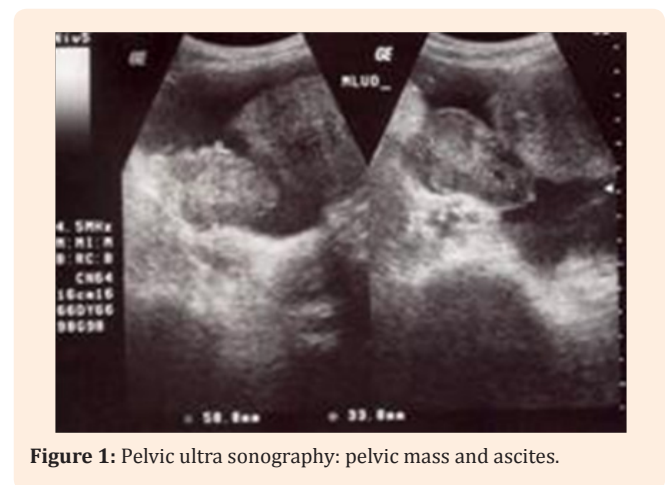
Pelvic ultra sonography: pelvic mass and ascites.
